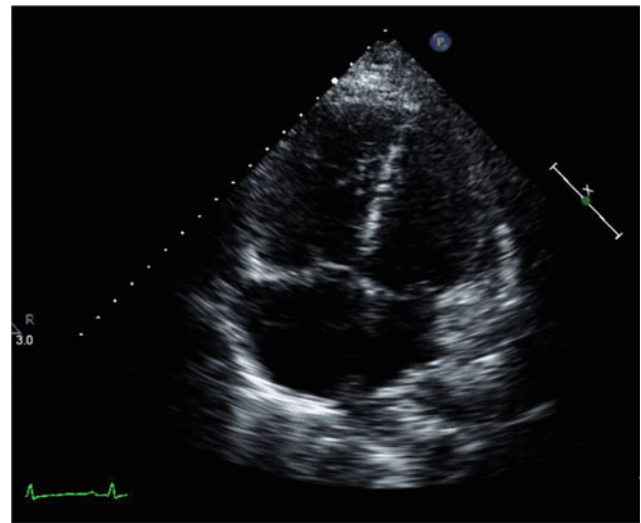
Echo image (apical four-chamber view) demonstrating a severely enlarged RV with a flattened septum consistent with RV pressure/volume overload in a 20-year-old woman with MDS who was admitted for allogeneic HCT. She had received antithymocyte globulin (ATG) to reduce the risk of GVHD, complicated by disseminated intravascular coagulation and severe pulmonary hypertension. Transplant was delayed to address the elevated pulmonary pressures and allow the right heart to recover
